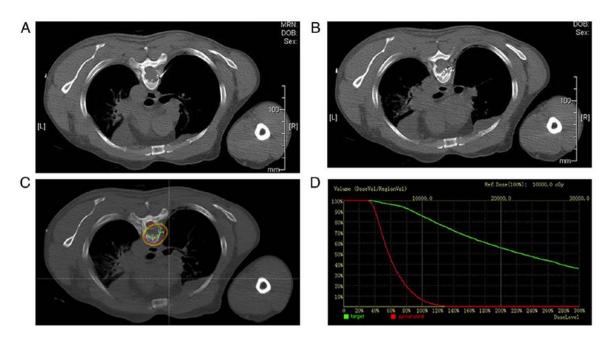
Post-implant CT scans following I-125 seed implantation. (A) The piercing process: An 18-gauge needle was inserted into the tumor to implant I-125 seeds, (B and C) Seed distributions and isodose curves of I-125 seed implantation, (D) Dose-volume histogram of the target tumor (green) and spinal cord (red).
